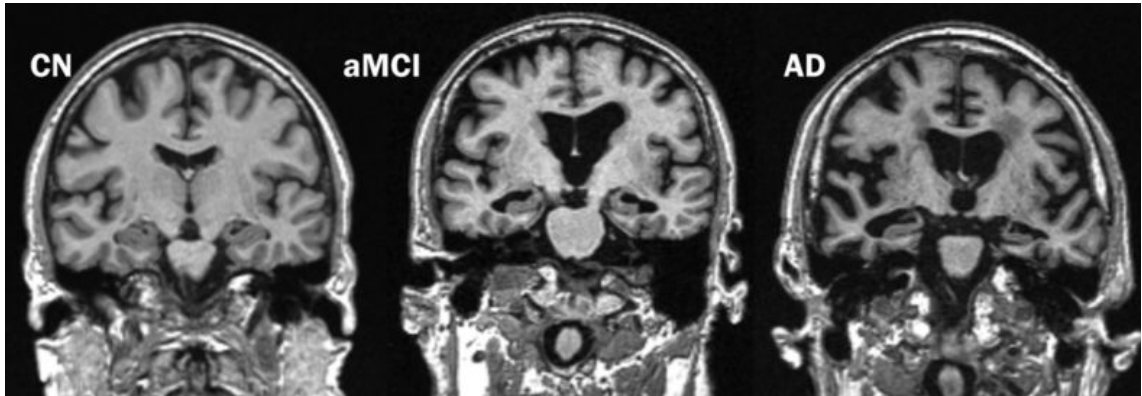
$T_1$  MRI scans showing progressive atrophy in a Cognitively Normal (CN) patient, an amnesic MCI (aMCI) patient, and an Alzheimer's Disease (AD) patient. Figure from Vemuri et al [1].
